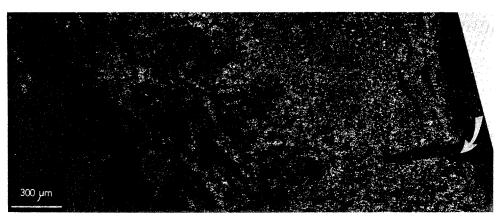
$K\alpha_{1,2}$ X-ray image of chromium distribution on the large rectangular field shown in Fig. 1b (scanning time: 150 s). Arrow indicates the fissure shown on Fig. 1b
